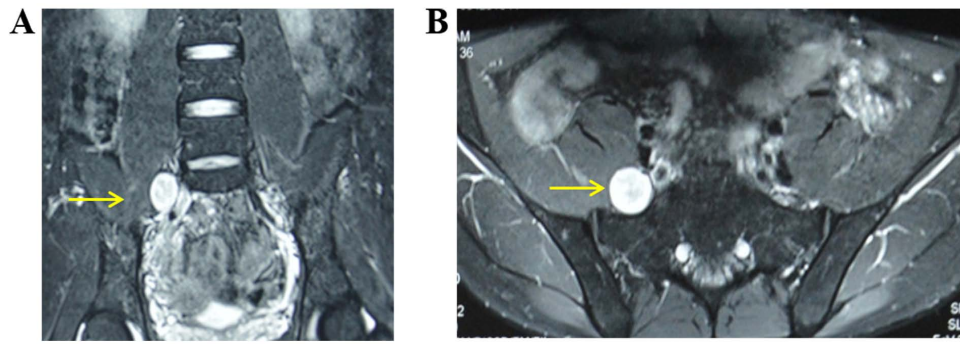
Preoperative pelvic magnetic resonance imaging plain scan and enhancement. The right L5 nerve root was 2.1x2.4x2.0 cm in (A) the coronal plane and (B) the transverse plane, with a clear boundary located at the medial edge of the psoas major, suggesting the high possibility of a nerve sheath tumor. Arrows indicate the area of the tumor.
